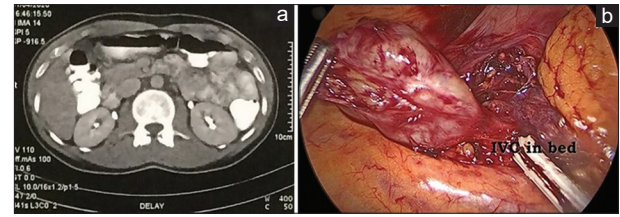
(a) Abdominal computed tomography scan demonstrating the retroperitoneal mass. (b) Intraoperative view of the retroperitoneal mass lying under the duodenum
